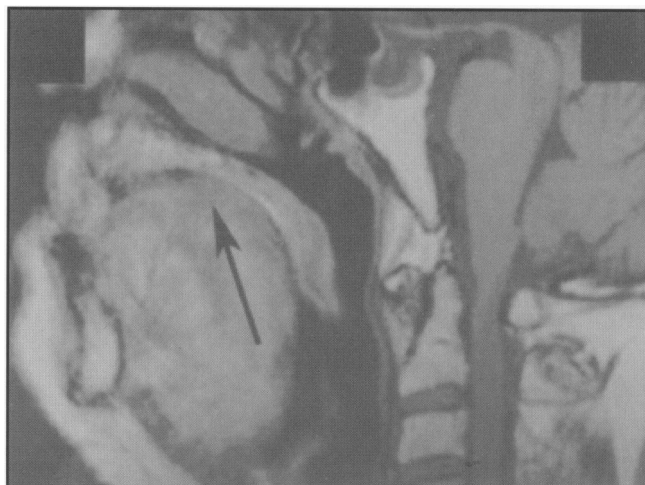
Sagittal T1-weighted MR image demonstrates a hypointense mass in the tongue (*arrow*).
